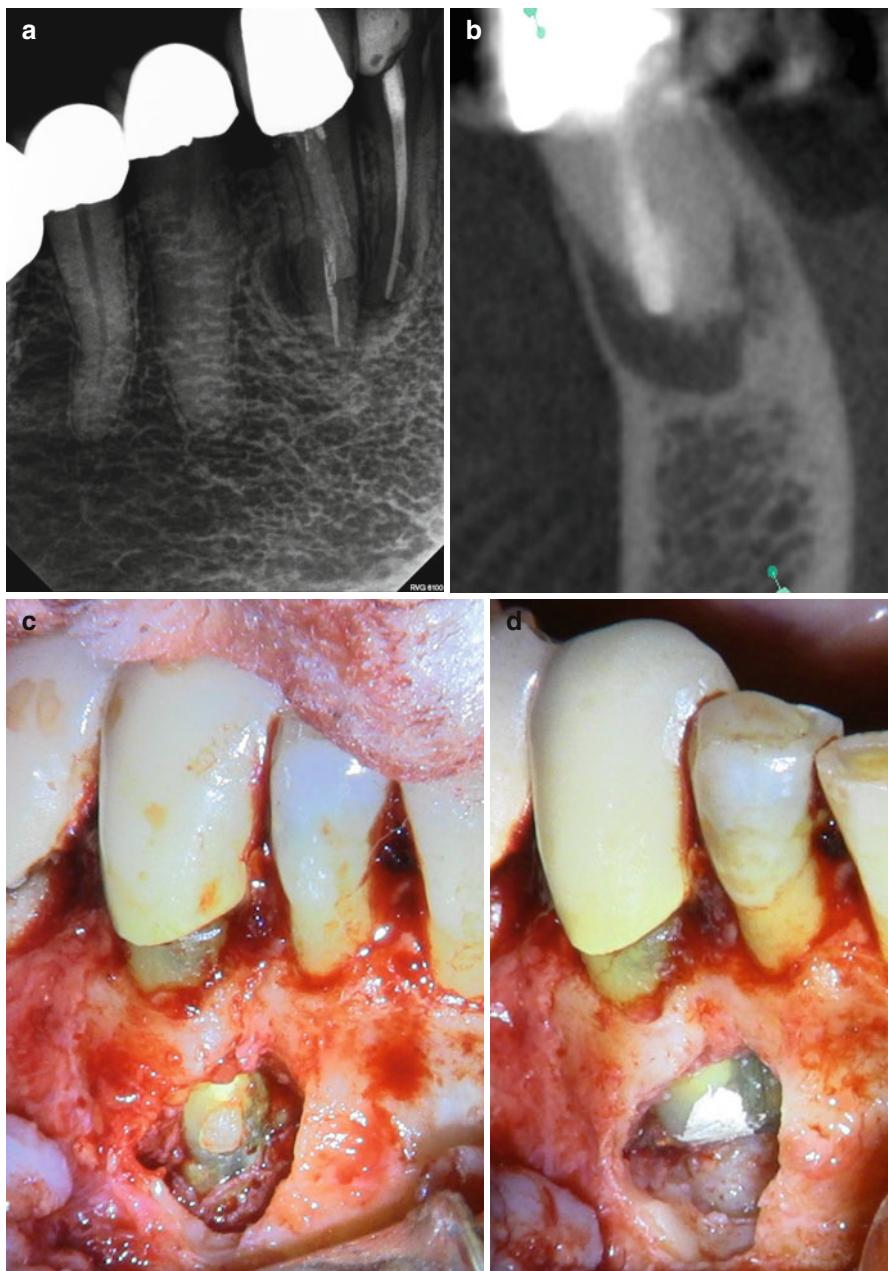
(a) Digital radiographic image of tooth #27 showing fiber post placement mesial to canal space. (b) Cone beam CT image showing post perforating facial aspect of root. (c) Surgical clinical image showing fiber post perforating mesial-facial aspect of root. (d) Surgical clinical image showing root end resection and repair of perforation (Clinical photos attributed to Dr. Cynthia Tyler, University of Minnesota Division of Endodontics)
